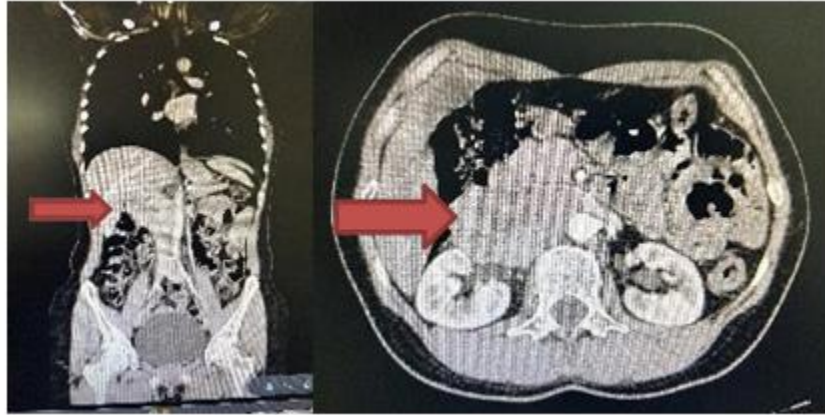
(A and B) Coronal and axial computed tomography angiography of the abdomen and pelvis, respectively, showing the tumor.
